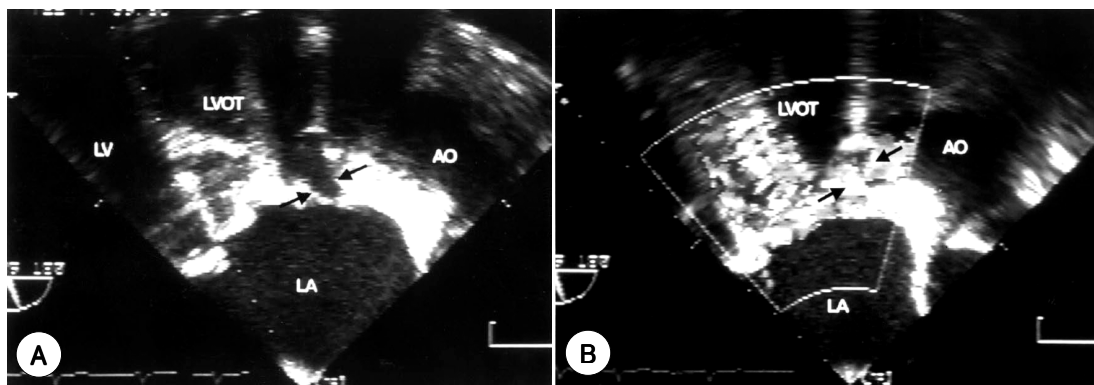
A : This transesophageal view shows cavitory defect in the MAIVF with fistulous connection to the aorta. B : This view demonstrates mosaic flow through the cavitory defect of MAIVF and this flow jet extends systolically to the left atrial side but definite flow communication could not documented.
